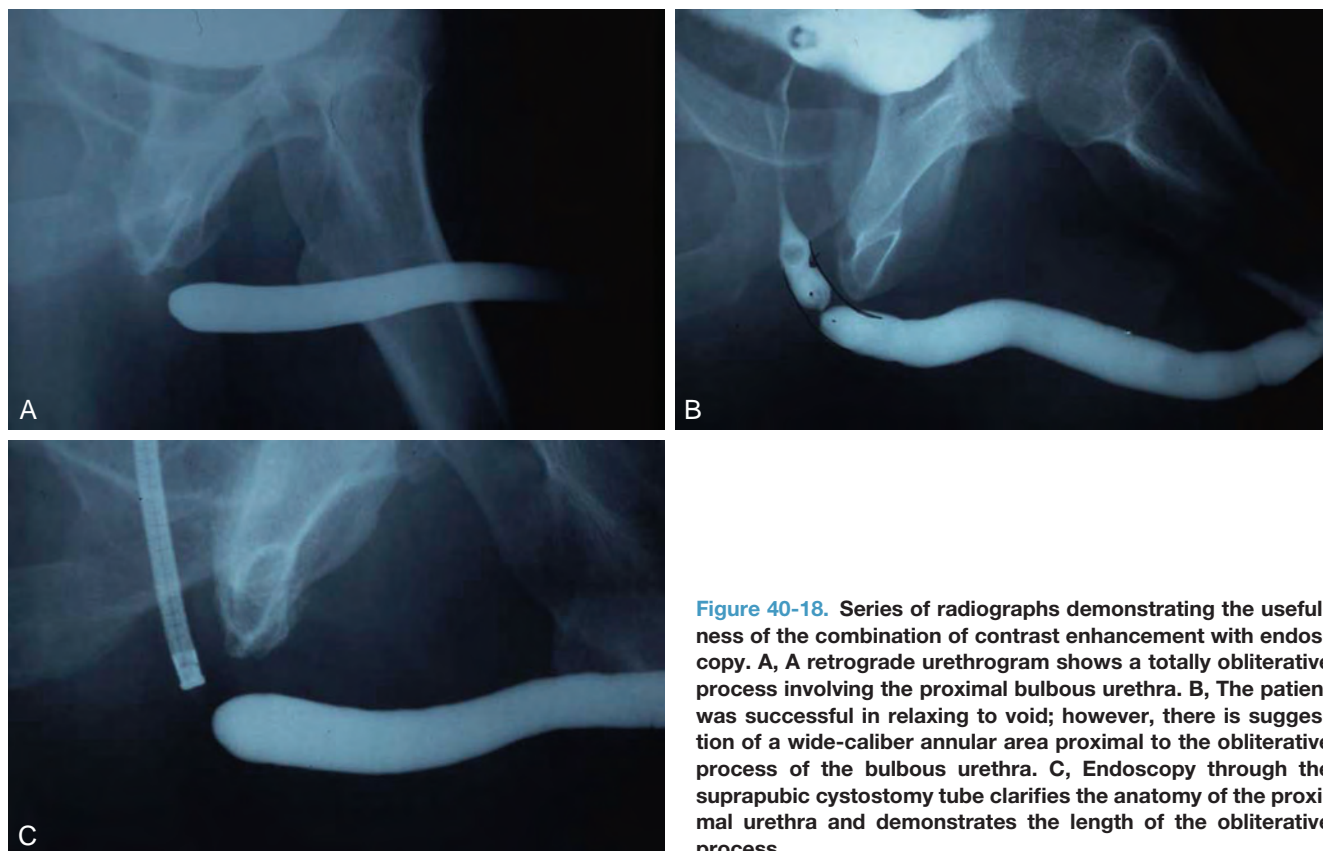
Series of radiographs demonstrating the usefulness of the combination of contrast enhancement with endoscopy. A, A retrograde urethrogram shows a totally obliterative process involving the proximal bulbous urethra. B, The patient was successful in relaxing to void; however, there is suggestion of a wide-caliber annular area proximal to the obliterative process of the bulbous urethra. C, Endoscopy through the suprapubic cystostomy tube clarifies the anatomy of the proximal urethra and demonstrates the length of the obliterative process.
